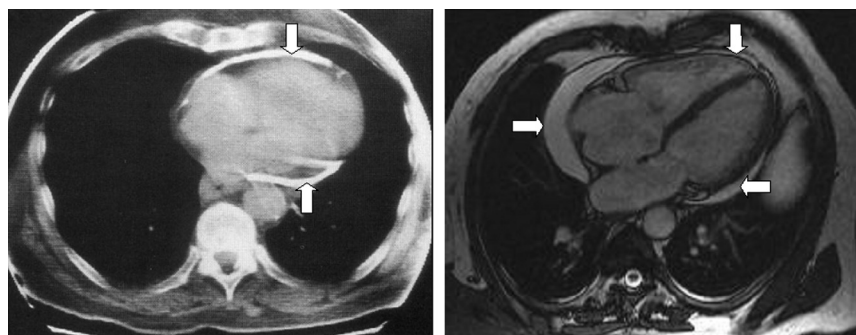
■ Computed tomography findings in constrictive pericarditis (left). White vertical arrows are depicting thickened pericardium and pericardial calcification. The magnetic resonance imaging results of a patient with effusive-constrictive pericarditis are shown in the right image. Horizontal arrows show a loculated pericardial effusion, and the vertical arrow shows thickened pericardium.
